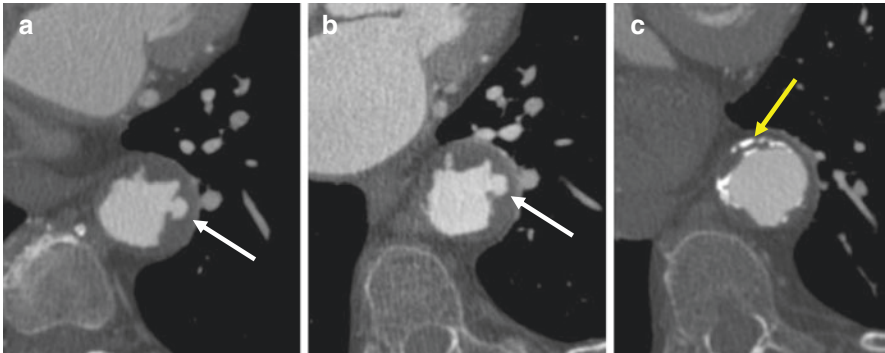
Axial CT images in a patient with no pertinent symptoms demonstrate irregular atheroma mimicking a PAU (white arrows). Images (a) & (c) are from the same study and image (b) from a study 5 months later. Notice the similarity of appearance of the fissured and excavated atheroma in images (a) and (c). Also, note the similarity of appearance to the lesion in Fig. 11. The plaque at this level has uniform low-density. Image (b) demonstrates calcification on both sides of the plaque in the anterior aorta (arrow). This should not be confused with the medially displaced plaque of IMH or dissection
